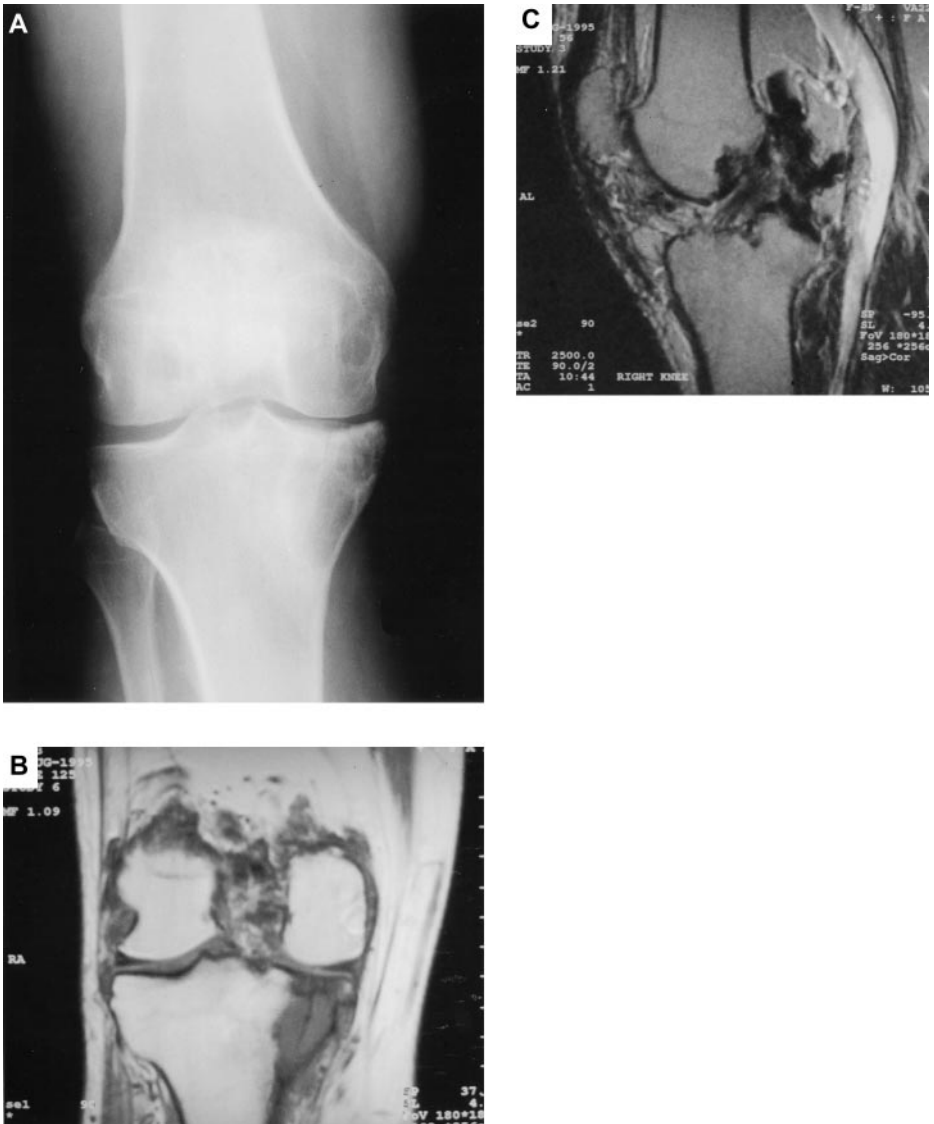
Pigmented villonodular synovitis of the knee. (A) Anteroposterior radiograph of the knee showing cystic changes in the medial femoral condyle and tibial plateau. The joint space is preserved and the bone density is otherwise normal. (B) A coronal T1-weighted magnetic resonance (MR) image shows low-signal hypertrophied synovium in the intercondylar notch and around the femoral condyles. The lesion in the medial tibial plateau has low signal on this image. On T2-weighted images, the signal in this lesion was high, compatible with a cyst. (C) On a sagittal T2-weighted MR image, hypertrophied synovium is low in signal posteriorly and has intermediate signal strength anteriorly. There is erosion and invasion of the adjacent femur and tibia.
